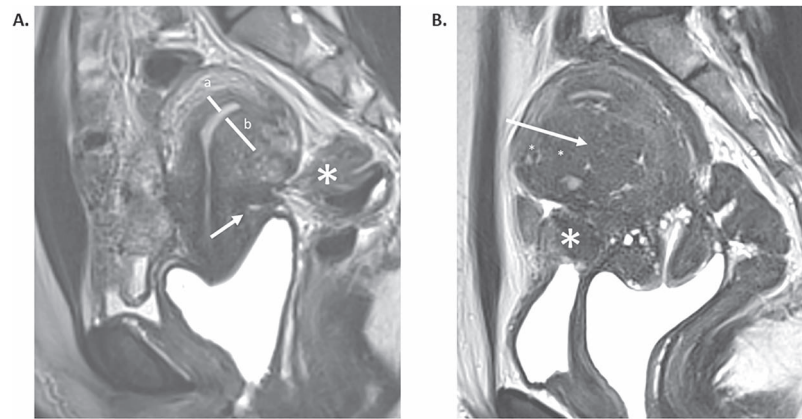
MRI sagittal T2-weighted images of focal adenomyosis and endometriosis. (A) posterior focal adenomyosis of the outer myometrium (FOAM) (white arrow). The lesion is contiguous to a deep infiltrating endometriosis (DIE) nodule affecting the uterine torus and the rectal wall (white star). Significant increased focal thickness of posterior junctional zone (b) (JZ) compared to the anterior JZ (a), suggesting a diffuse internal adenomyosis. (B) Anterior FOAM (white arrow) with the presence of intramyometrial cysts (small white stars). The lesion is contiguous to a bladder nodule of deep infiltrating endometriosis (DIE) (big white star).
